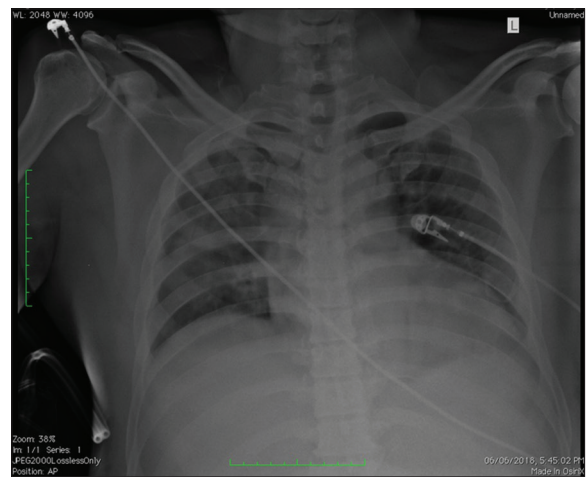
Chest X-ray showing multiple rib fractures on both sides
